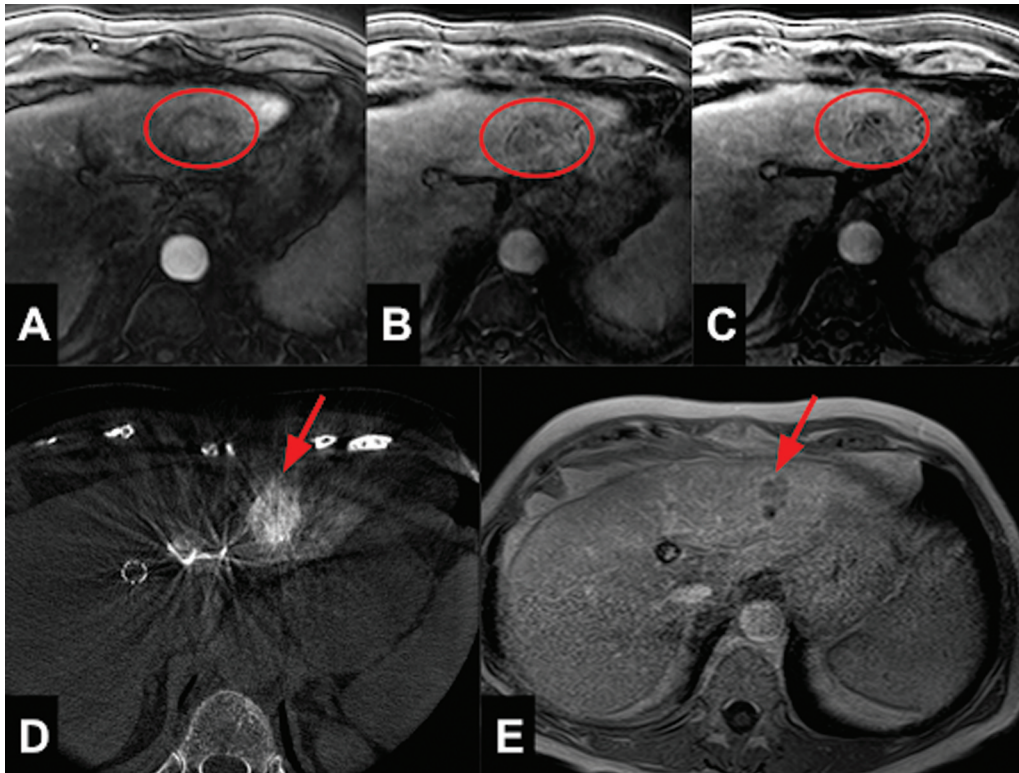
(A) Pretreatment magnetic resonance imaging (MRI): Axial T1 post-contrast sequence in early arterial phase demonstrating 2.9 cm arterial enhancing lesion in segment 2 of the liver (circle), categorized as LI-RADS 4 lesion. Post-contrast T1-weighted images in the portal venous phase (B) and delayed phase (C) demonstrating contrast washout in the lesion (circle). (D) Pre-yttrium 90 planning computed tomography image demonstrating arterial enhancing lesion in segment 2 (arrow). (E) 3-month post-treatment MRI, post-contrast axial T1 weighted sequence with fat suppression showing the decreased size and absent enhancement in the treated lesion (arrow). LI-RADS, liver imaging reporting and data system.
